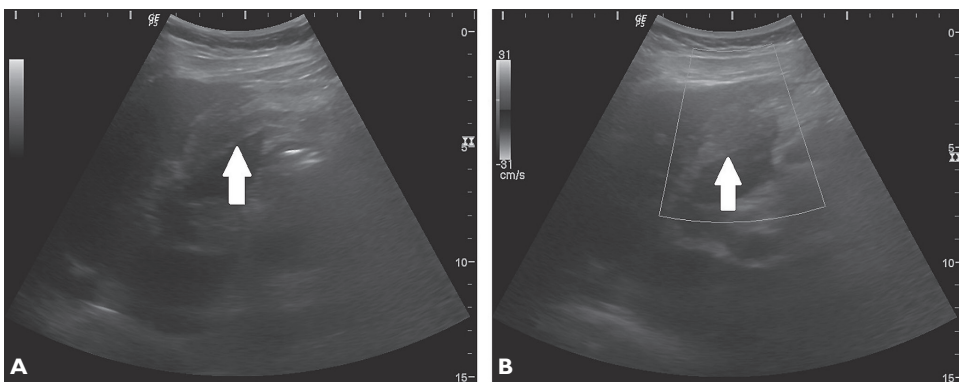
Ultrasonography demonstrated a heterogeneous image, predominantly echogenic, elongated in A, without vascularization on the Doppler study between hepatic segments IV and II/III in B, compatible with torsion of the falciform ligament (white arrow).
